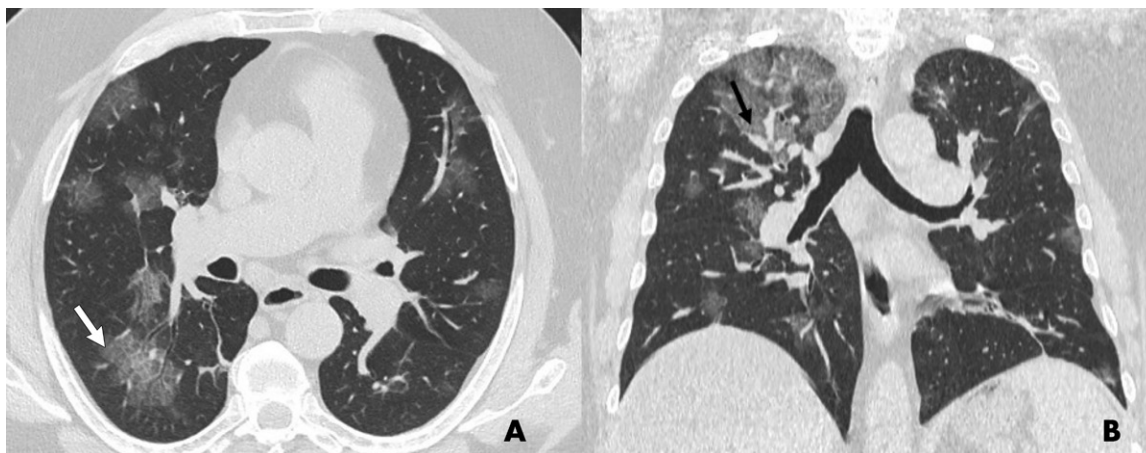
Axial and coronal thin-section unenhanced CT scan in a 65-year-old man with unknown exposure history who presented with fever and cough. A, Chest CT shows diffuse bilateral confluent and predominantly linear ground-glass opacities with a pronounced peripheral distribution and consolidation with an air bronchogram (arrow). B, Coronal thin-section unenhanced CT scan shows diffuse bronchiectasis of both lower lobes (arrows).
